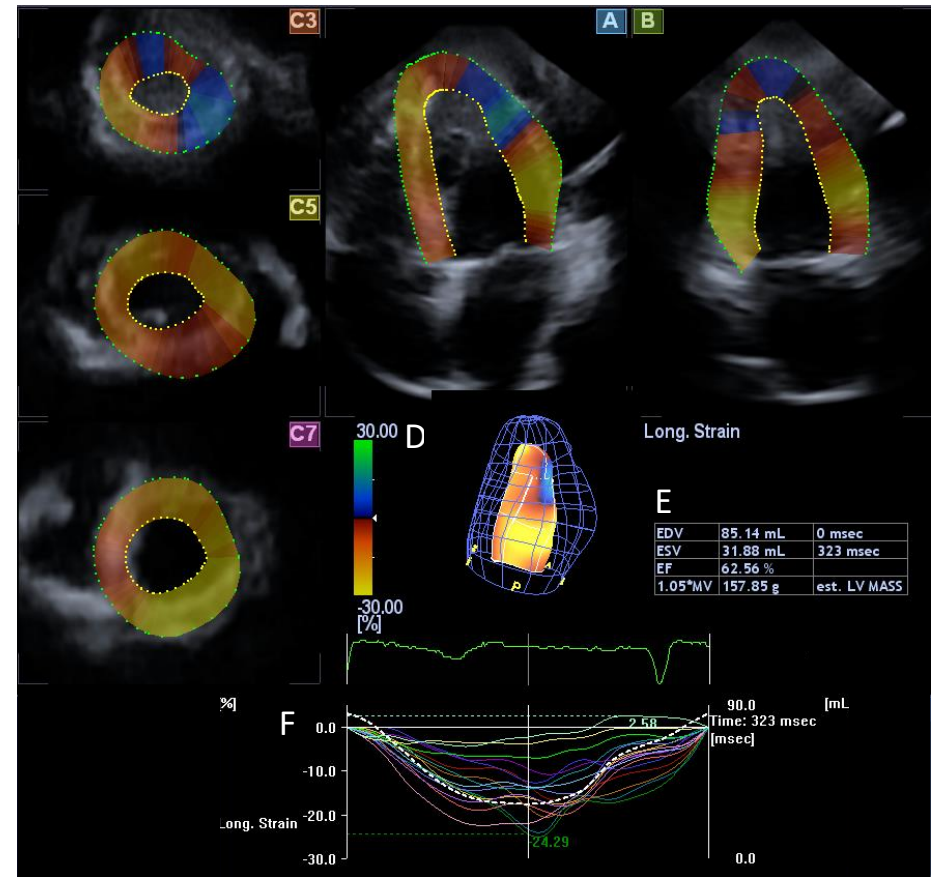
3DSTE of the left ventricle of a healthy adult (panel 1) and a patient with hypereosinophilia syndrome (panel 2). From the 3D echocardiographic database collected by the special transducer, the software automatically creates sections corresponding to apical four chamber- (A) and apical two chamber views (B), and apical (C3), midventricular (C5) and basal (C7) segments in the defined cross-sectional planes. The virtual 3D model of the left ventricle (D) is automatically generated by the software after the endocardium has been detected and then the left-ventricular volumetric data, ejection fraction (E) and global / segmental strain curves (F) are calculated.
